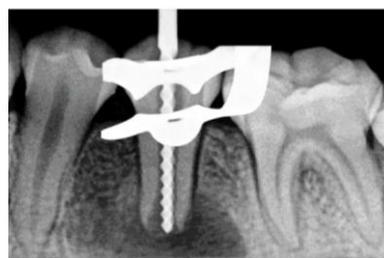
Estimation of Working length in 45 with the help of intraoral periapical radiograph (IOPA)
